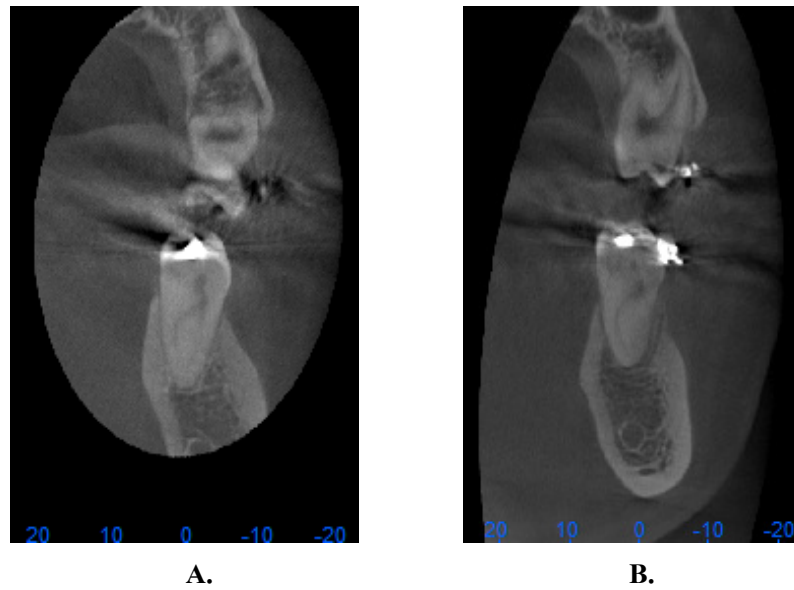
CBCT (coronal section) was used to compare the buccal and lingual marginal bone level before decortications (A) and 3 months after extraction space closed (B).
